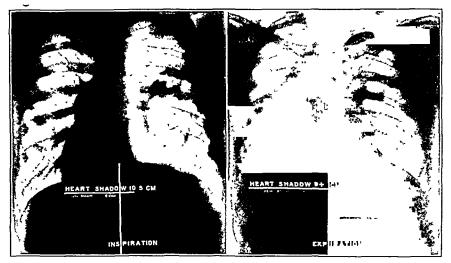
(case 1).—Inspiration and expiration, postero-anterior view of a man, aged 27. Right-sided pneumothorax induced for progressive unilateral disease with increasing cavity formation. Duration of pneumothorax, six months. Amounts of air given from 300 to 600 cc., usually about 400 cc. Maximum end-pressures given, +3 cm. of water. Tests of sputum still positive. The roentgenograms show a deviation of the mediastinum to the left, just 3 cm., rotation of the mediastinum posteriorly into the left side of the chest being shown by diminution of the heart's greatest transverse diameter from 10.5 to 9.0 cm.
